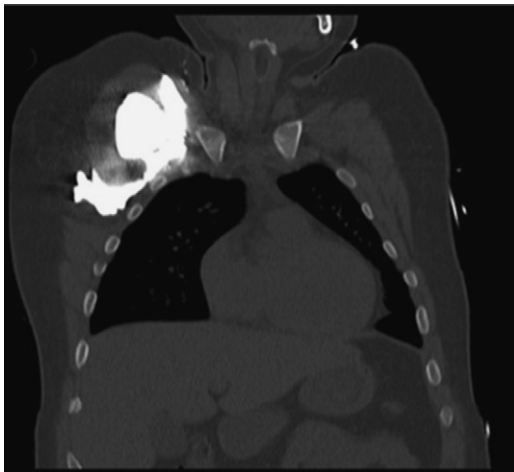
Coronal thoracic CT scan identifying IV contrast anterior to the clavicle and deep to the pectoralis major muscle. Notice the lack of contrast within the right pleural space or the venous system.
